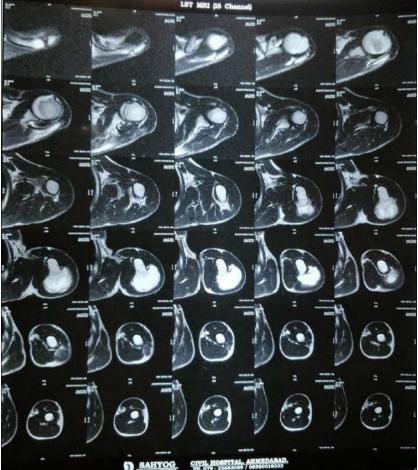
MRI scan pre-operatively
